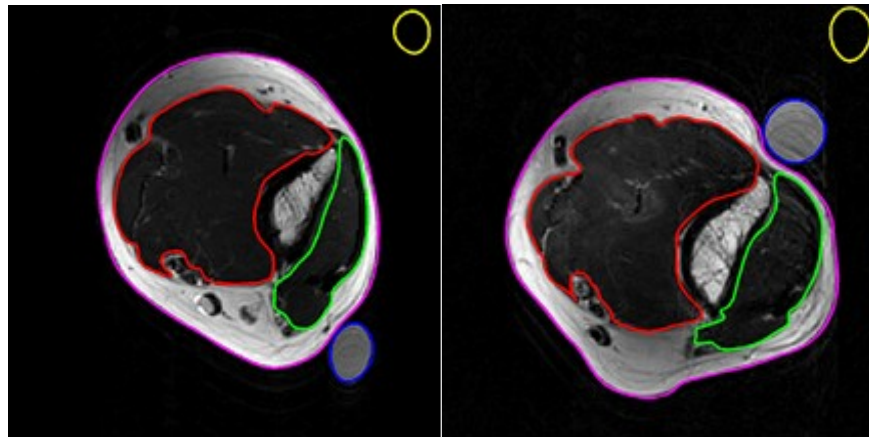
MRI slices from HFHR subject. Left panel is baseline scan and the right panel is two days post-exercise. Note the increased signal in the elbow flexors in the right panel (indicative of edema, CNR=9.9).
